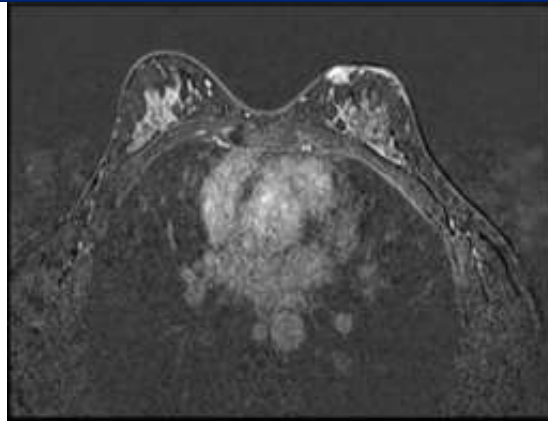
Breast MRI showing in sequence injected a lesion which enhances after
